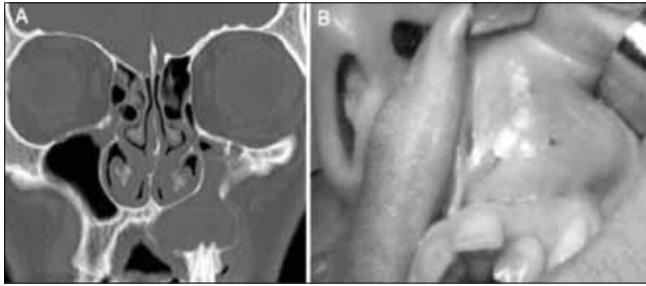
Patient 6. SCDDT resulting from odontogenic cyst (Class 3a). A) Coronal maxillofacial CT, and B) clinical examination showing a bulging of the upper gingiva caused by the cyst.
